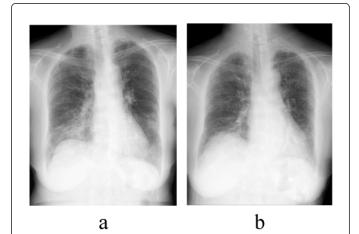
Chest X-ray on the initial visit (Figure 1a) showed reticular shadows in the bilateral lower lung fields which improved after the first steroid pulse therapy. At the time of re-hospitalization (Figure 1b), both lungs showed reticular shadows predominantly at the periphery with reduced lung volume.
